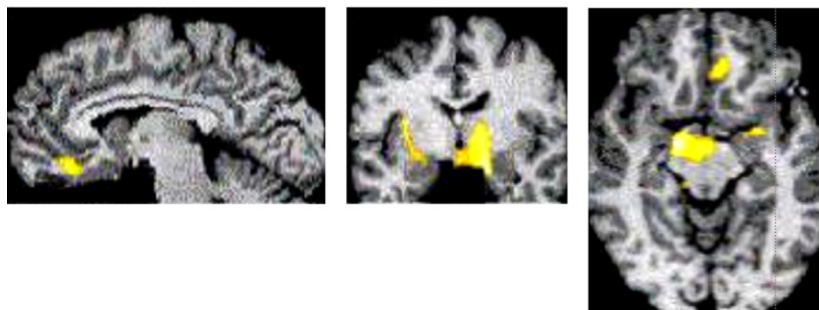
MRI sections normalized according to the Talairach space, showing regions with significant ($z > 3.5$) increases of blood flow during motor cortex stimulation, including the thalamus ipsilateral to stimulation, the insular and subgenual cingulate/orbitofrontal cortices, and the brainstem. No significant rCBF change was observed in the motor or somatosensory cortices directly underlying the stimulator (reprinted with permission from Garcia-Larrea et al., 1999).
